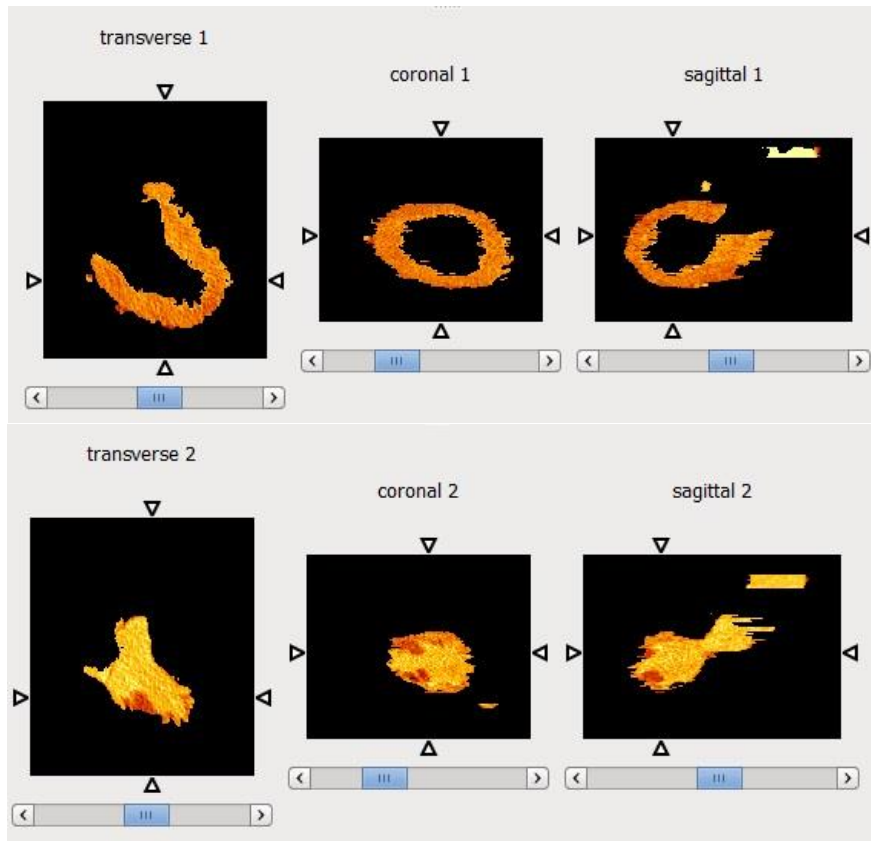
Results from segmenting the LV (top) and BP (bottom) of a selected CTA image, using the active contour segmentation technique
